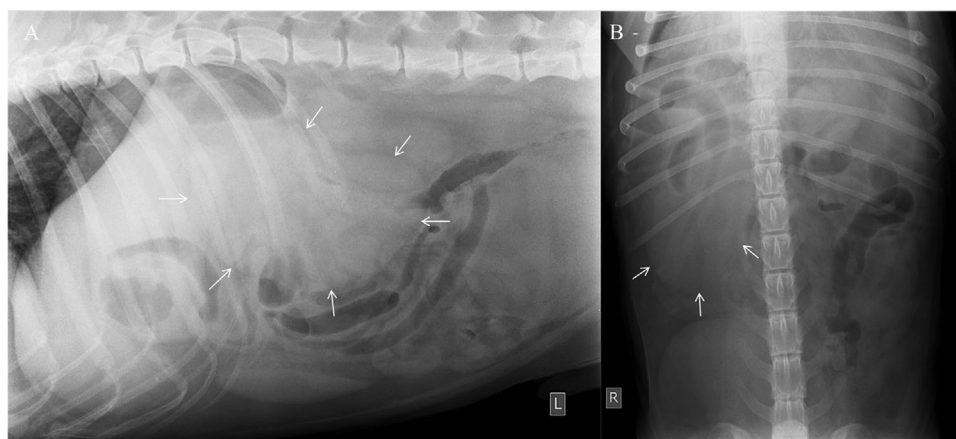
Left lateral (A) and ventrodorsal (B) abdominal radiographs. Silhouette of the right kidney (arrows) is enlarged extending from T13 to L4, showing a ventral displacement of the intestinal loops. Loss of serosal detail in the cranial abdomen is also observed
